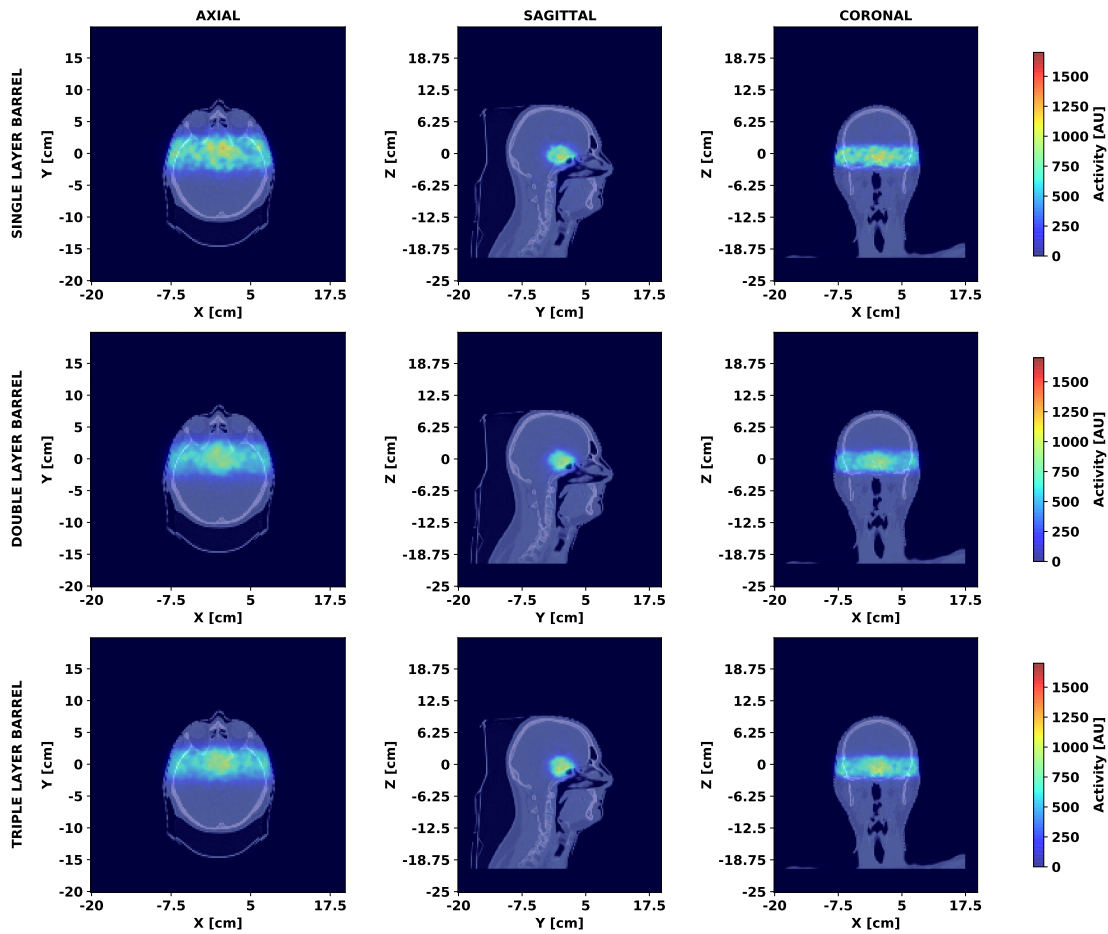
Reconstructed PET images superimposed on CT images for single layer barrel (top), double layer barrel (middle) and triple layer barrel (bottom) configurations in axial (left), sagittal (centre) and coronal (right) views.
